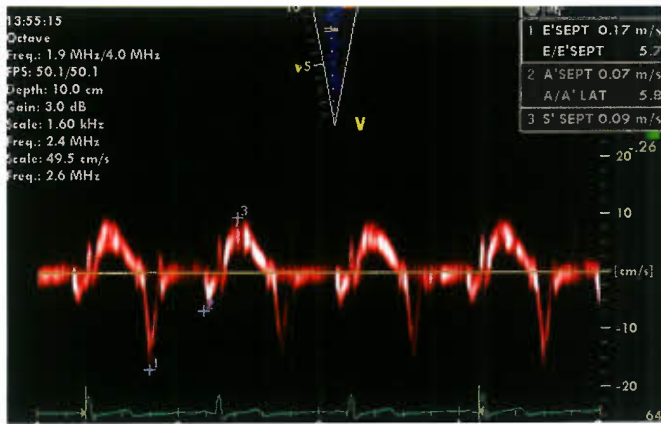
Typical longitudinal tissue Doppler tracing obtained in the basal part of the interventricular septum from an apical four-chamber view. Alignment with longitudinal LV motion is extremely important to obtain reliable measurements. Peak systolic velocity (S') (3), peak early diastolic velocity (E') (1), and peak late diastolic velocity (A') (2) are measured.
